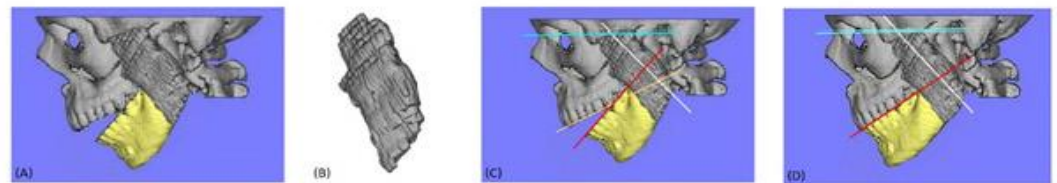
3-D MRI showing detail of masseter muscle fibre bundle orientation (A and B). Favourable change in muscle length and fibre orientation following maxillary impaction and mandibular advancement surgery for closure of anterior open bite (C, D).
